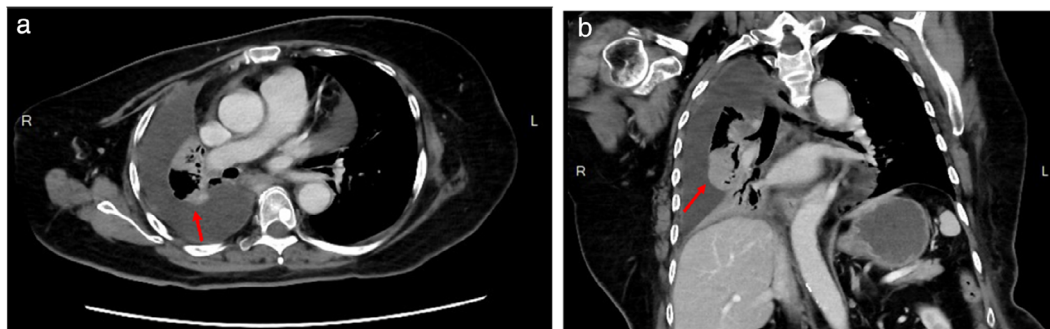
Follow-up chest CT with contrast enhancement after treatment with osimertinib for 3 months revealed a partial response of the lung tumor but disease progressive of the osseous metastases on the thoracic spine
